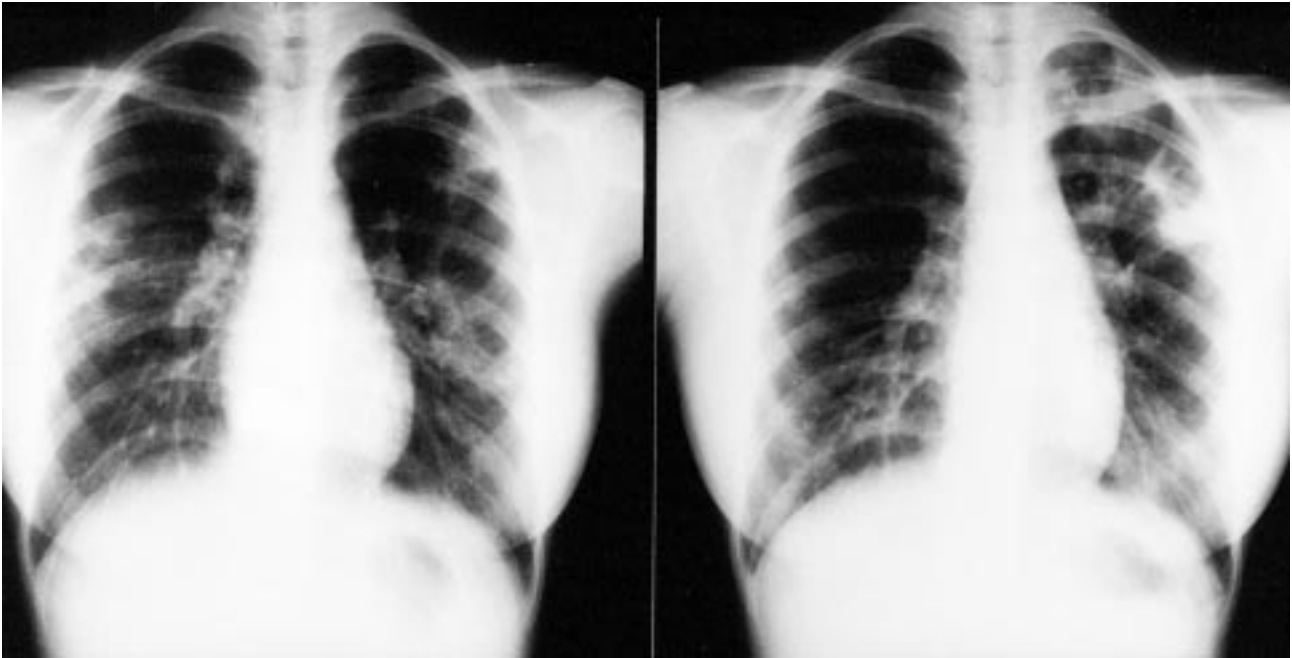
Chest roentgenogram 2 weeks prior to admission demonstrated small dense infiltrates in the right middle and left upper lobes (left). On admission, a small dense consolidation appeared in the left upper lobe (right).
